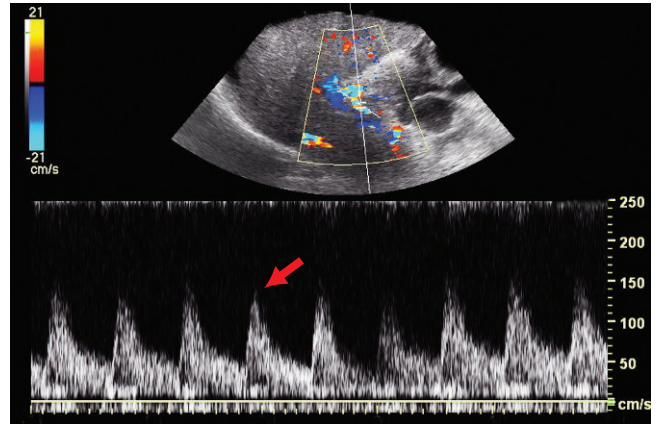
The duplex and color Doppler sonographic image of the liver shows aliasing in the hepatic artery indicating a high velocity as evidenced by the high peak systolic velocity of the arterial waveform (arrow).
